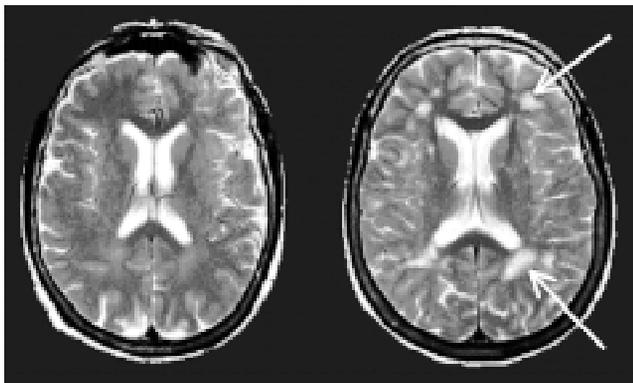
T2-weighted MRI exams of two 65-year-old individuals. The subject on the left has no apparent subclinical brain lesions on this slice whereas the subject on the right has a severe grade of white matter hyperintensities (arrows)
